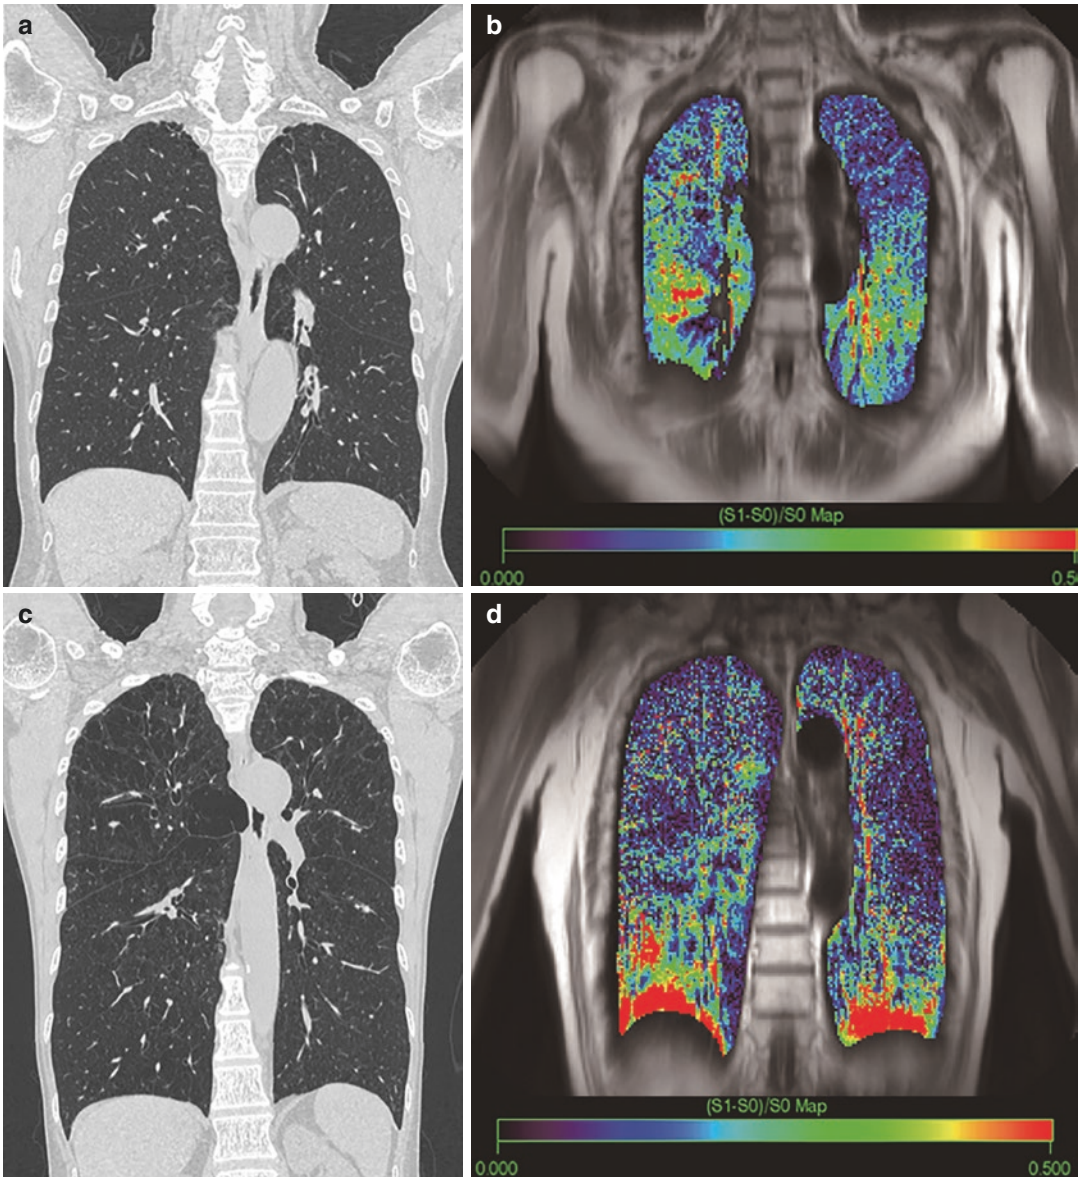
Oxygen-enhanced MRI in COPD patients. (a, b) A 75-year-old female smoker with mild COPD (a: thin-section coronal multiplanar reformatted (MPR) CT image shows centrilobular emphysema in the left upper lung field, b: relative enhancement (RER) map from oxygen O_2 -enhanced MRI demonstrates heterogeneously decreased oxygen-enhancement in the both lung, especially left upper lung field.) (c, d) a 56-year-old female
